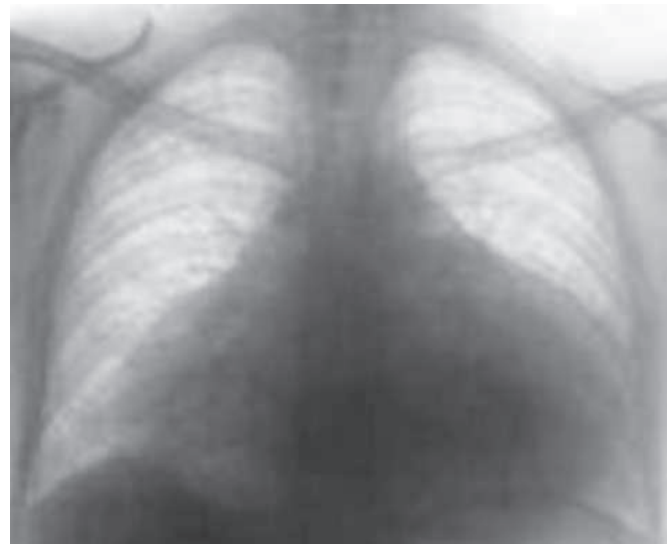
Chest radiograph showing cardiomegaly in a patient with cardiac tamponade
